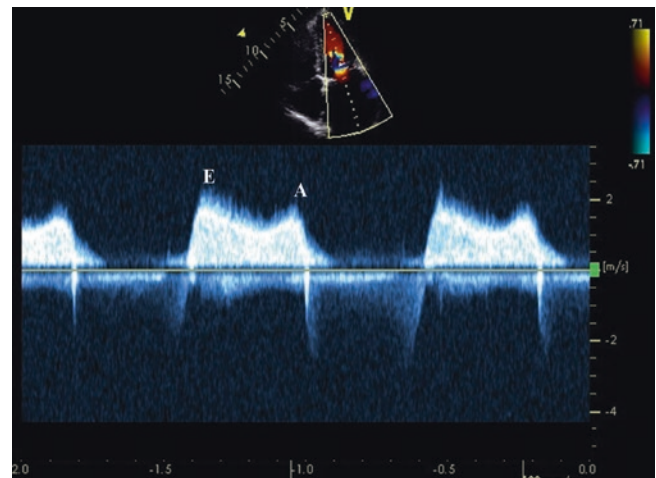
Mitral inflow interrogation using continuous wave Doppler. In ultrasound systems equipped with spectral Doppler continuous wave interrogation through the mitral valve can be obtained. Early diastolic velocity (E) is high exceeding 2 m/sec and the deceleration slope of E wave appears flat. This is consistent with significant mitral stenosis. Atrial contraction wave (A) is not seen in patients with atrial fibrillation. Tracing the contour of the spectral Doppler signal can be used to calculate mean transmitral gradient
